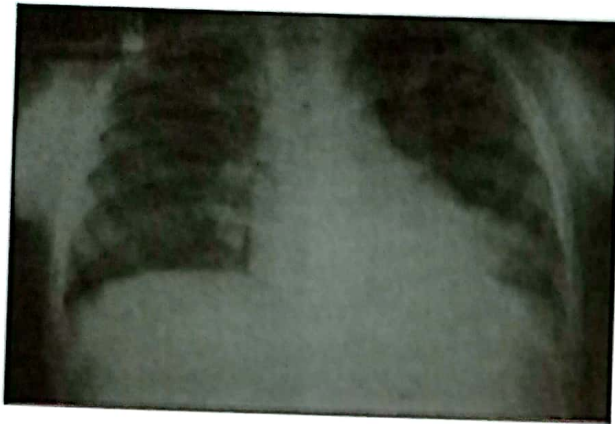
X-ray chest of case 1, showing patchy opacities
